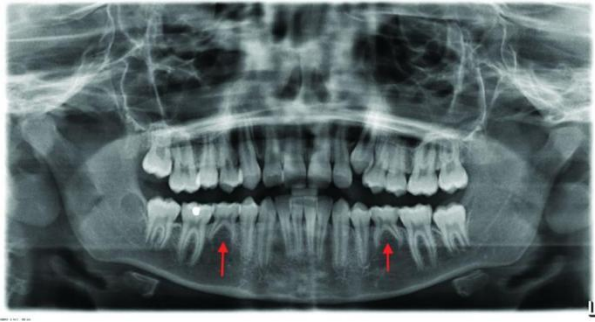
Panoramic radiography of mandibular agenesis teeth.
